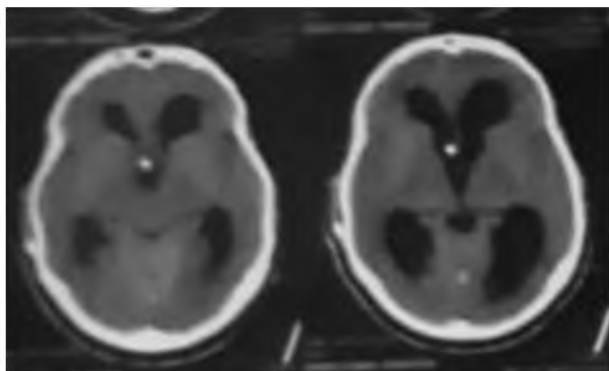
The post-operative CT of the same patient showing the removal of the lesion and placement of shunt.
